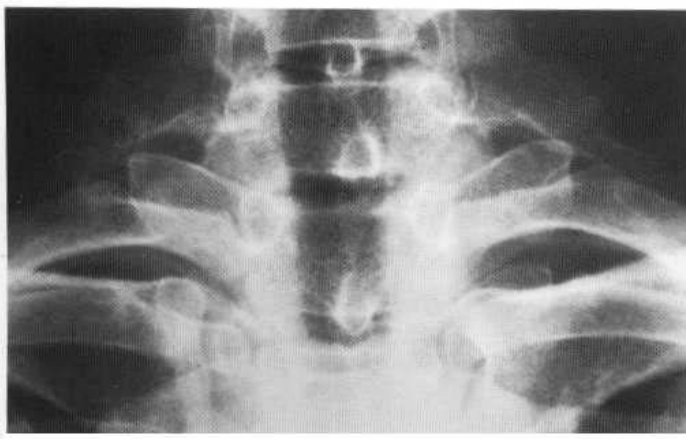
Cervical rib. The cervical rib originates from a transverse process which points downwards. Thoracic ribs originate from upward-pointing transverse processes. (A) On the plain radiograph the well-corticated and ossified cervical ribs are shown originating from the C7 transverse processes. (B) At MR imaging the lesions are less well defined (arrows), but any associated fibrous attachments are seen with this imaging modality.
